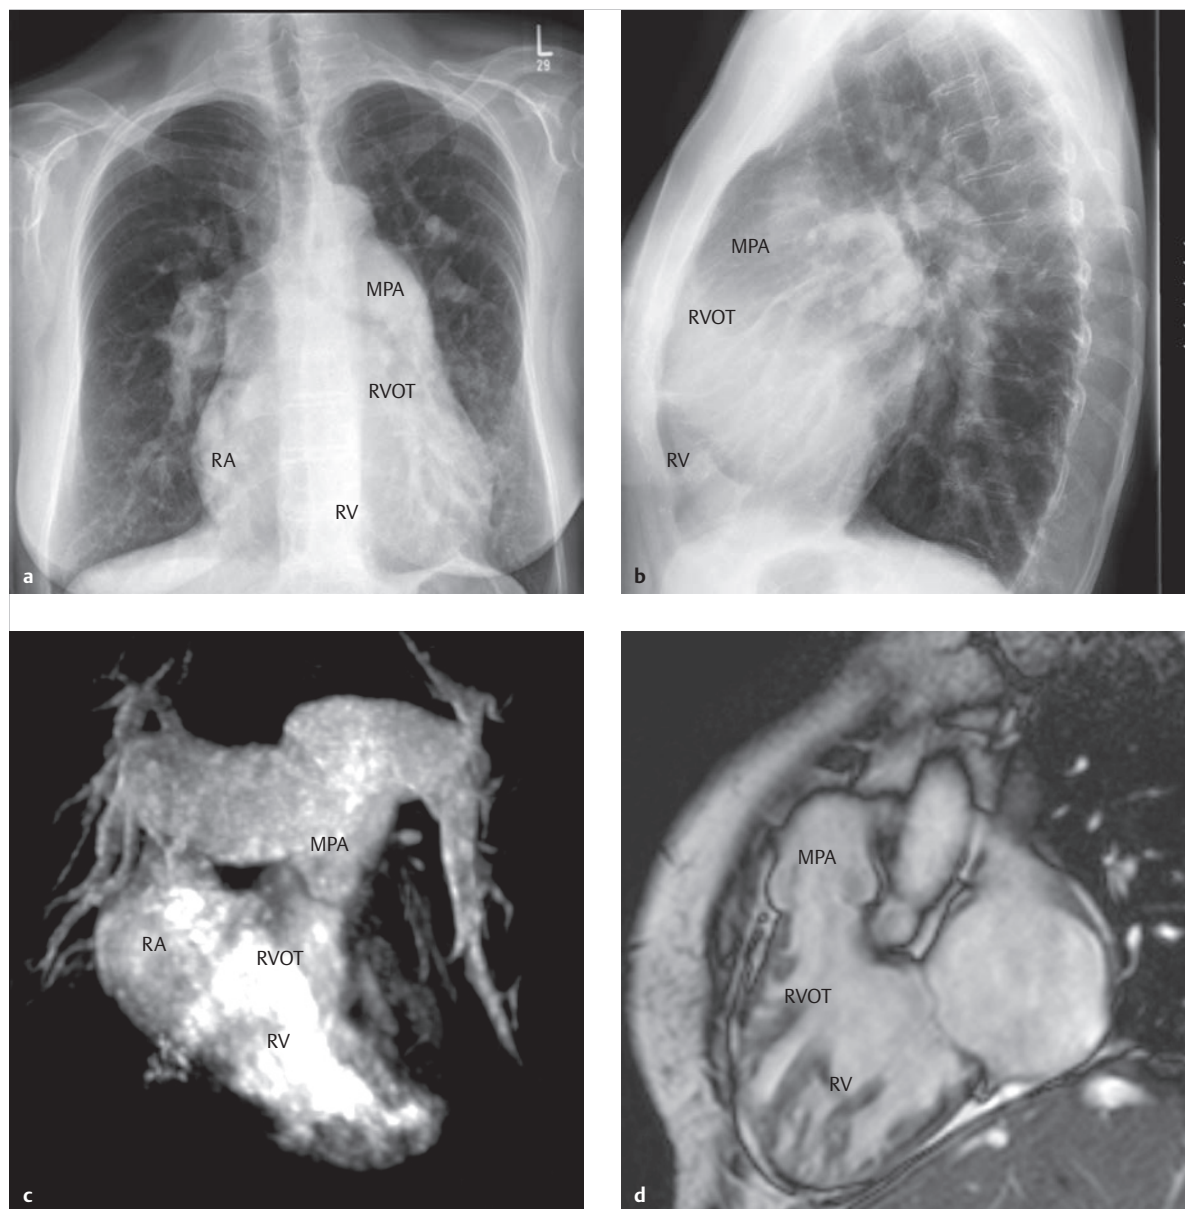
ASD accompanied by dilation of the pulmonary vessels. Thoracic X-rays (a, b) of an adult male patient with significant dilation of the main pulmonary artery (MPA) and branches, right atrium, right ventricle, and RVOT, as well as a volume overload in the lungs. The MIP reconstruction of a contrast-enhanced MRA (c) and right ventricular long axis of an SSFP cine MRI sequence during systole (d) depicts the dilated right ventricle of the same patient, and the significantly dilated right and left pulmonary arteries.
